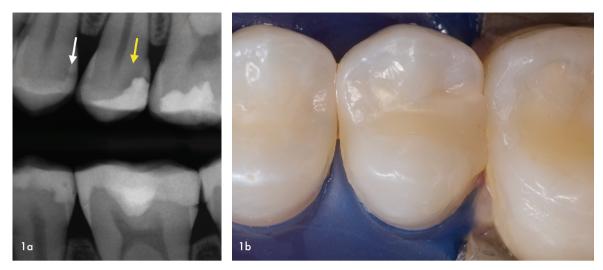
a) Pre-operative bitewing radiograph showing caries distally on the 24 (white arrow) and secondary caries beneath an existing restoration on the 25 (yellow arrow); b) Pre-operative clinical view under high magnification.
